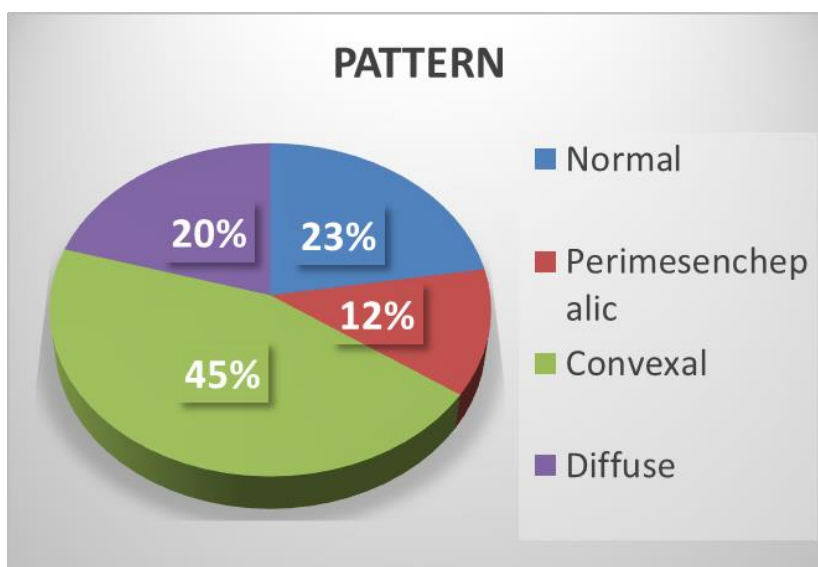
Pie chart showing distribution of SAH on Plane CT Brain, with 23% being normal study, 12% of them showing perimesencephalic distribution of SAH, 45% of them showing convexal distribution of SAH and 20% of them showing diffuse distribution of SAH.
